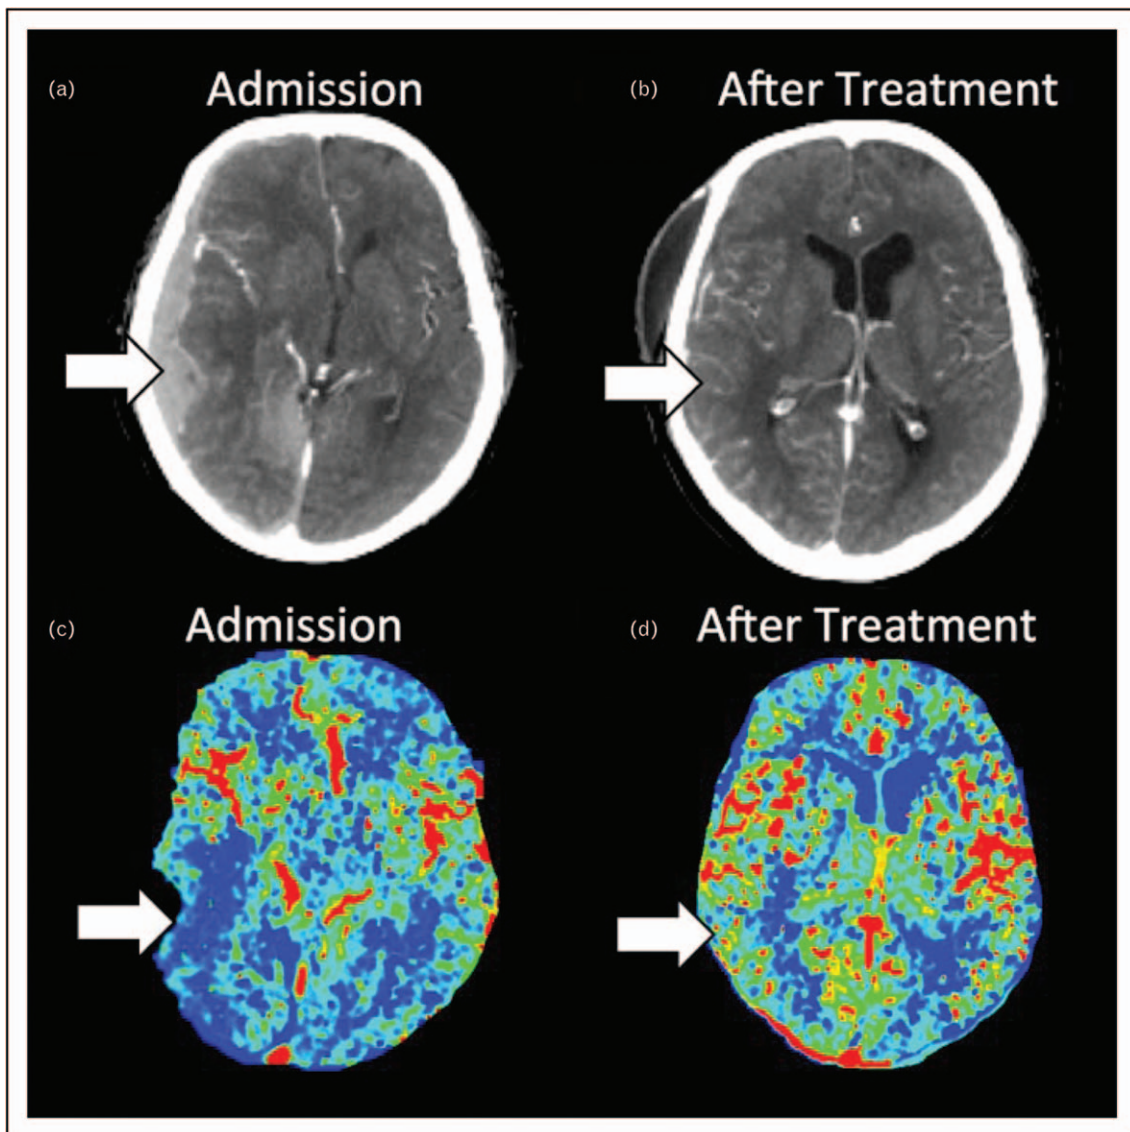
Contrast-enhanced and perfusion computed tomography images from a patient with severe traumatic brain injury. (a) Contrast-enhanced computed tomography imaging at admission demonstrates a right-sided subdural hematoma causing mass effect on the underlying brain and midline shift. (c) Regional cerebral blood flow perfusion computed tomography imaging at admission demonstrates decreased regional cerebral blood flow in the underlying right temporal lobe. (b) Contrast-enhanced computed tomography image after surgical evacuation of the hematoma demonstrates resolution of the right-sided subdural hematoma, mass effect and midline shift. (d) Regional cerebral blood volume perfusion computed tomography imaging after surgical evacuation of the right-sided hematoma demonstrates normalization of the regional cerebral blood flow in the right temporal lobe. Reprinted with permission [37*].
